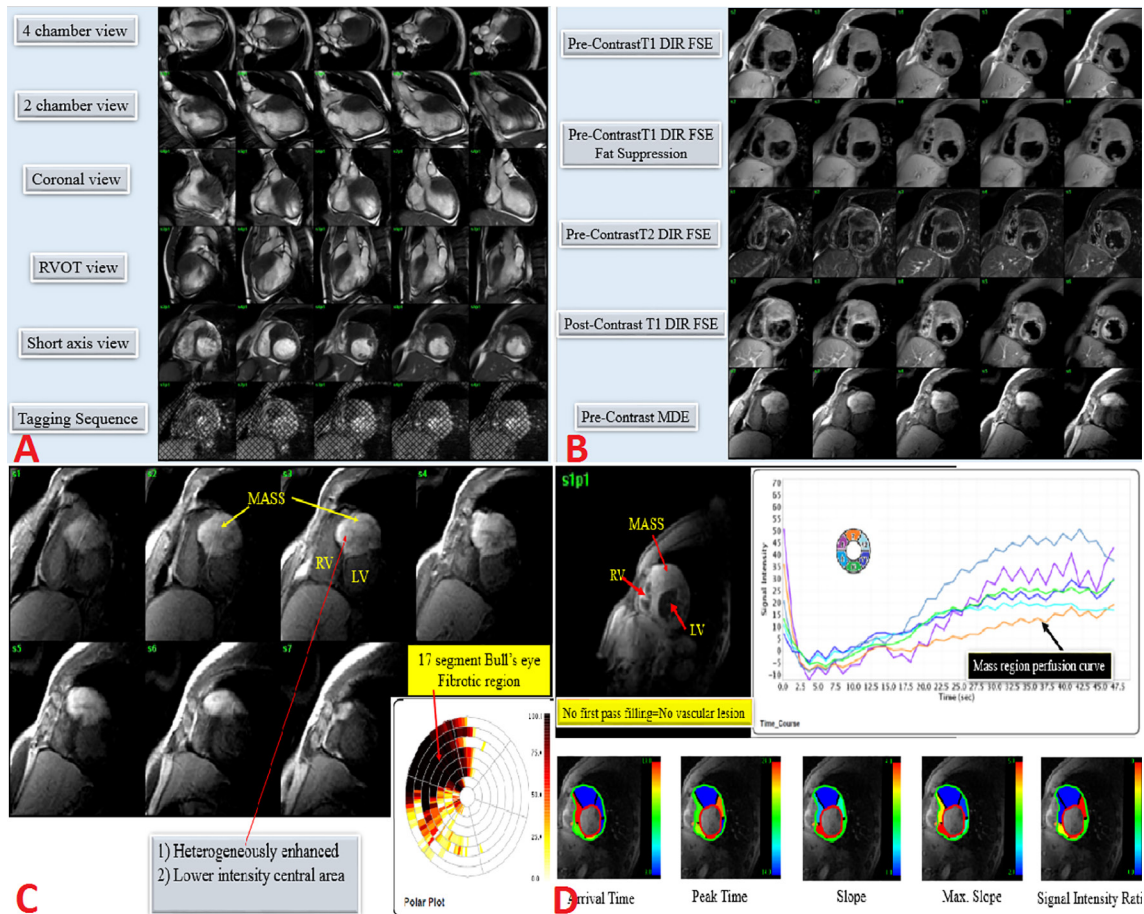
(A). FIESTA Different Views Showing a Hypointense Mass in the Interventricular Septum; (B). Different T1 and T2 MRI Views with or without Contrast Injection; (C). Myocardial Delayed Enhancement 15 Min after Gadolinium Injection; (D). Myocardial Perfusion Imaging, First Pass Study
